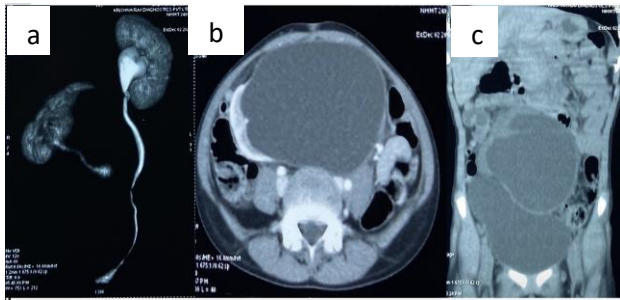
(a) CT Urograph 3-D reconstruction; showing right ectopic kidney in right iliac fossa (b) axial section (white arrow) and (c) coronal section (black arrow) of CECT abdomen showing grossly dilated right pelvis.
